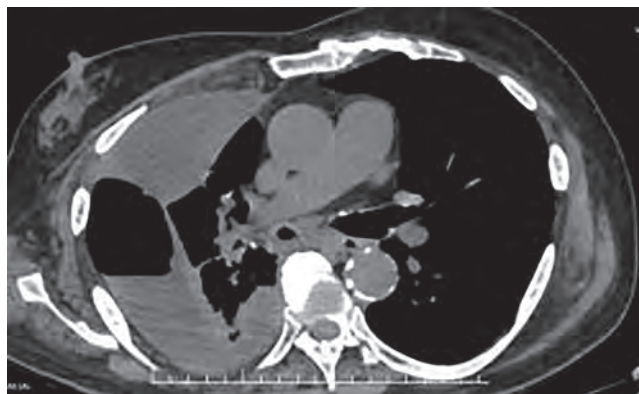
CT thorax showing lesion in right intermediate bronchus
